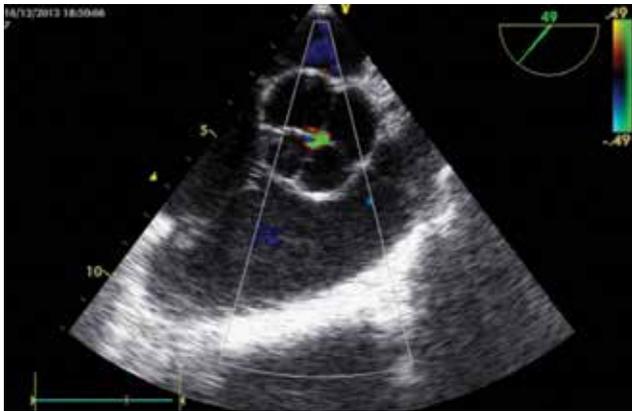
Transesophageal echocardiography revealed mild aortic regurgitation
